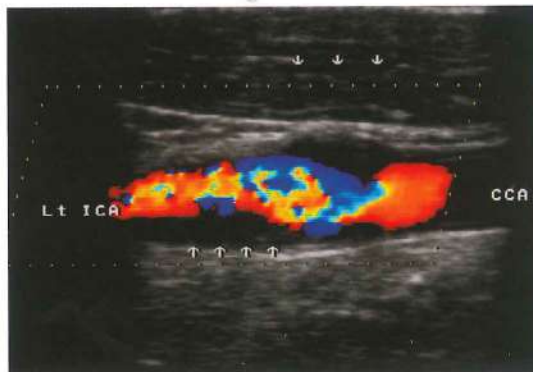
Carotid stenosis (moderate grade) on Color Doppler (Duplex) Flow Imaging.
